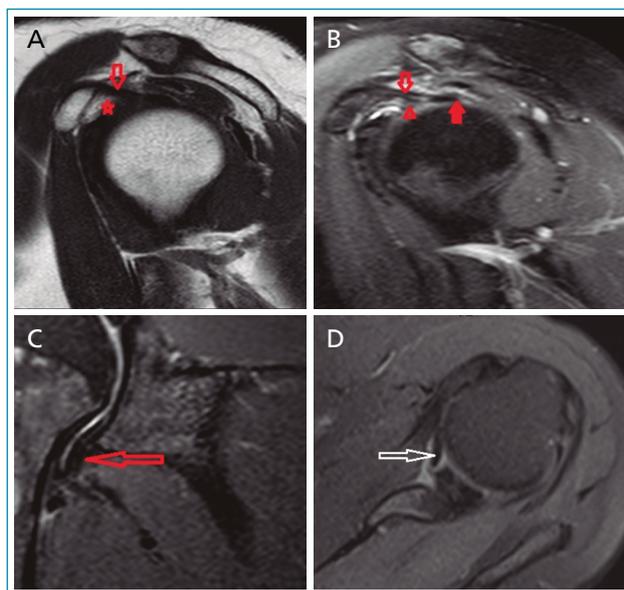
(A) Sagittal oblique magnetic resonance T1-weighted examination on the left shows slight thickening of the coracohumeral ligament (area marked with a hollow arrow) and mild obliteration in the subcoracoid fat tissue (marked with an asterisk). (B) Proton density-weighted sequence examination shows thickened coracohumeral ligament (area marked with a hollow arrow), fluid and soft-tissue increase in the rotator interval (area marked with an arrowhead), and signal increase at the biceps attachment point (area marked with a solid arrow). (C) In the coronal oblique plane right shoulder magnetic resonance imaging proton density-weighted sequence, thickened inferior glenohumeral ligament is seen (marked with arrow). (D) Proton density-weighted magnetic resonance imaging in the axial plane of the left shoulder showed significantly thickened superior glenohumeral ligament (marked with arrow).
